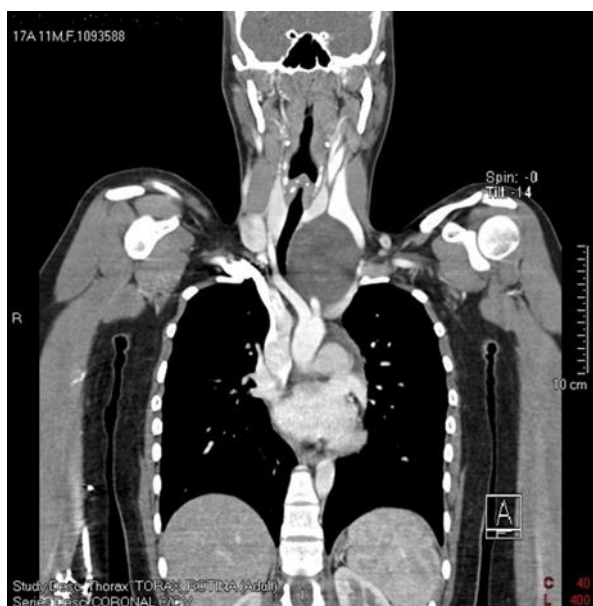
Coronal CT scan showing an expansive lesion in the posterior inferior cervical region of the left lobe of the thyroid with extension to the superior mediastinum.
